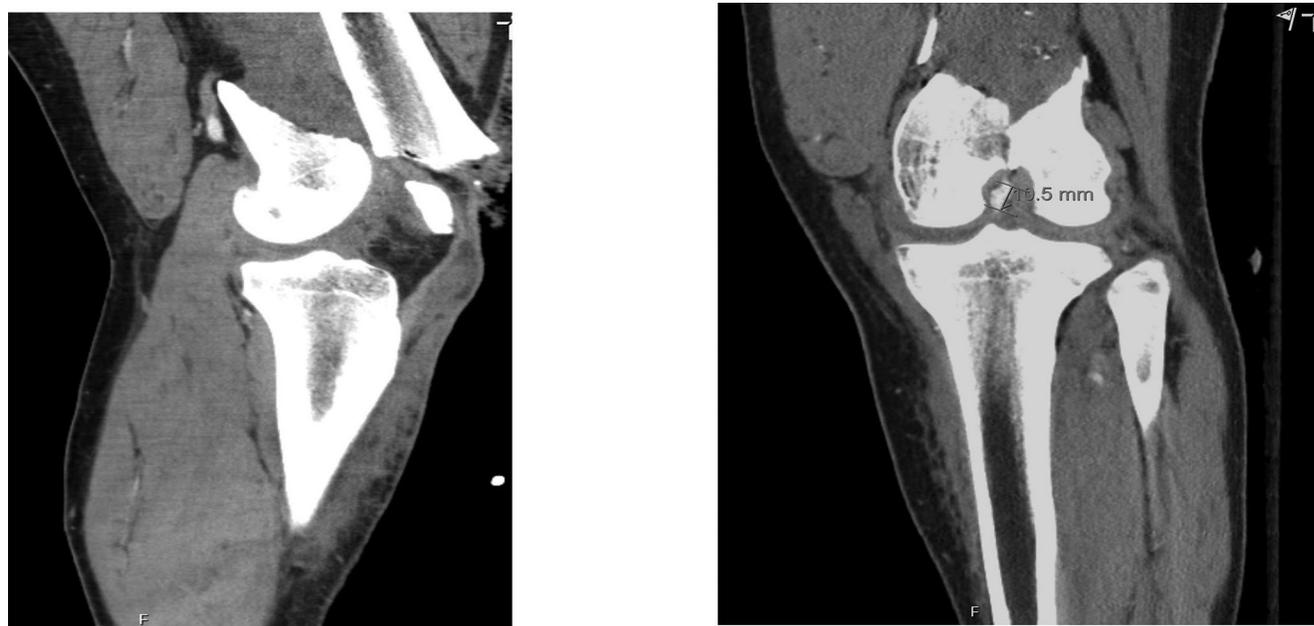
Preoperative CT imaging. Lateral view (left) and anteroposterior (right): Open comminuted fracture of the distal femoral metaphysis with intra-articular extension into the intercondylar notch.
